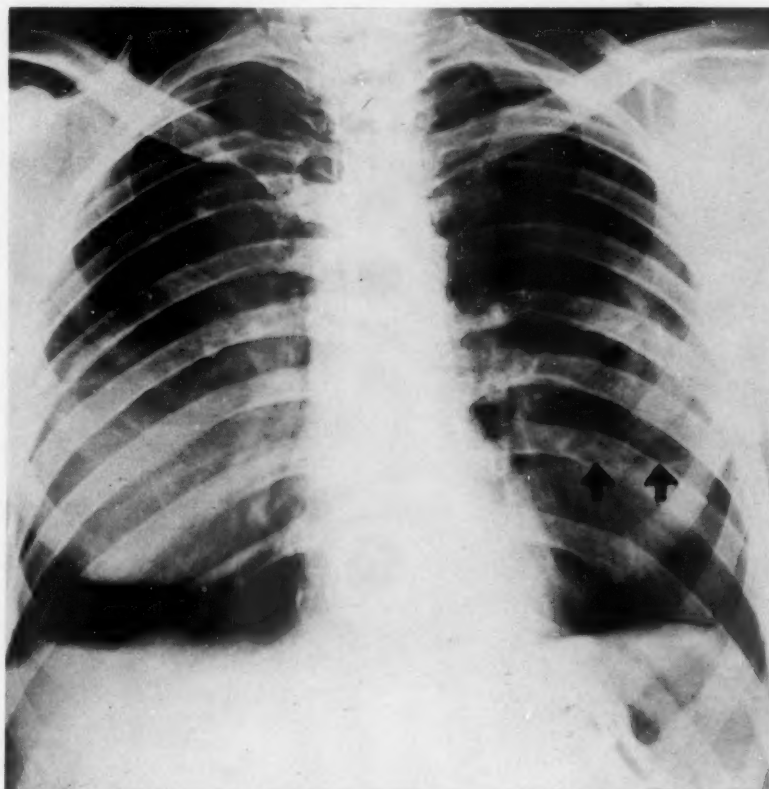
Case 12, Table I: Postero-anterior roentgenogram demonstrating bilateral pleural effusion with fluid level on left side.
